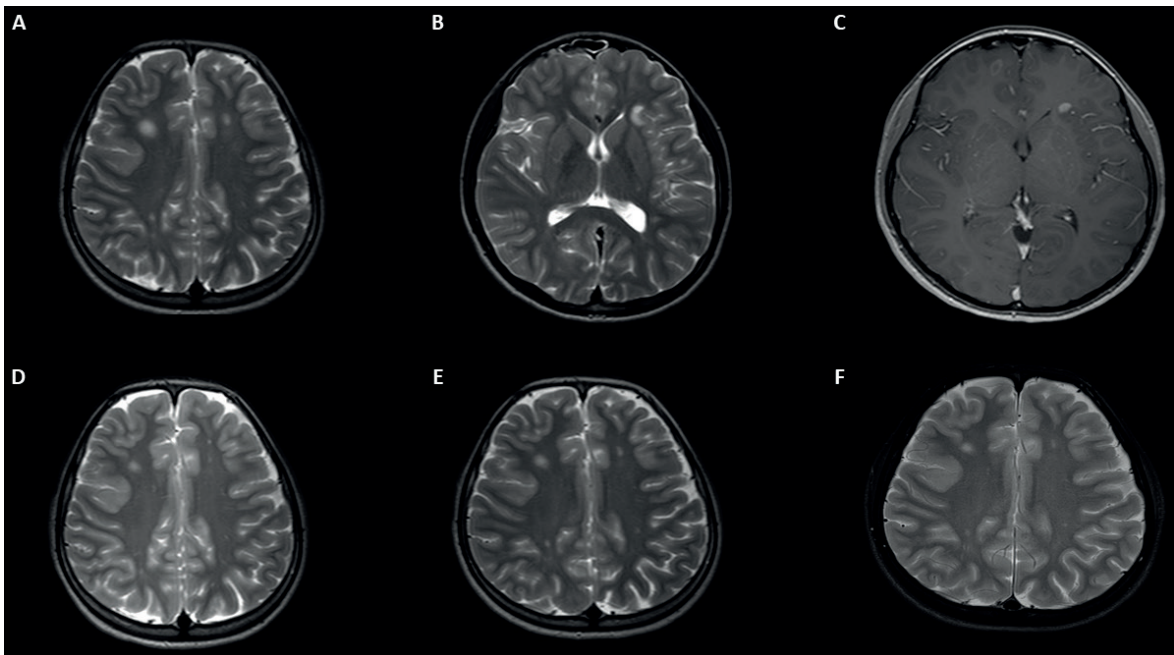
A-C. MR images at admission. Axial T2-weighted images showed white matter lesions in both cerebral hemispheres (A, B); Axial T1-weighted images after gadolinium administration demonstrated enhancements and also ring enhancement of right frontal subcortical lesion (C). D-F. Axial T2-weighted images at one month, one year and 2,5 years later (respectively), lesions were significantly decreased and contrast enhancement after gadolinium administration had disappeared. There was no new lesion.
